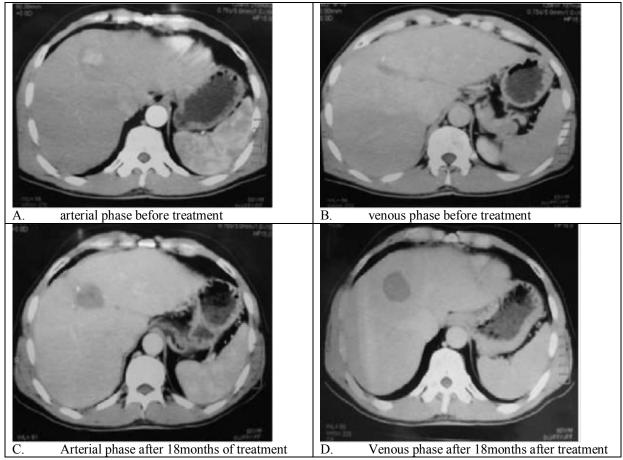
Dynamic computed tomography of patient with single focal Rt. Lobe lesion before and 18 months after combined ablation therapy showed complete ablation necrosis.
